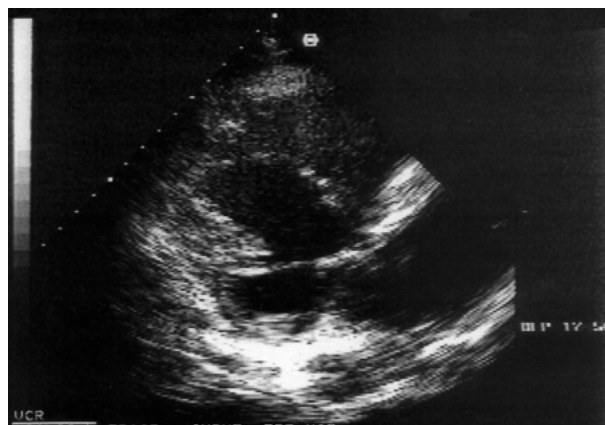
Echocardiogram of the case patient subsequent to thrombolytic therapy and the development of progressive neurologic deterioration. The previously visualized calcified thrombus has disappeared.
